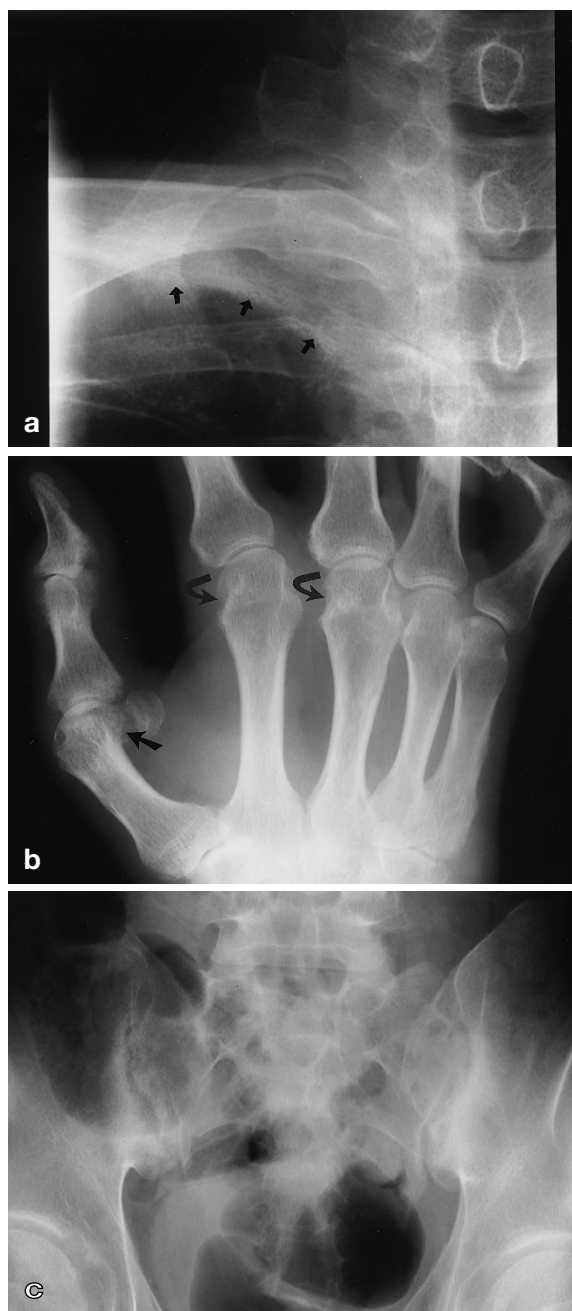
A 37-year-old man with GPP. a A close-up anteroposterior view of the cervical spine shows erosion in the right costoclavicular joint, and a fine, linear periosteal reaction in the clavicle (*arrows*). b An oblique posteroanterior radiographic view of the right hand shows marginal erosion and joint space narrowing from the first to third metacarpophalangeal joints and the interphalangeal joint of the first finger (*arrows*). c An anteroposterior radiographic view of the pelvis reveals symmetric sacroiliitis
